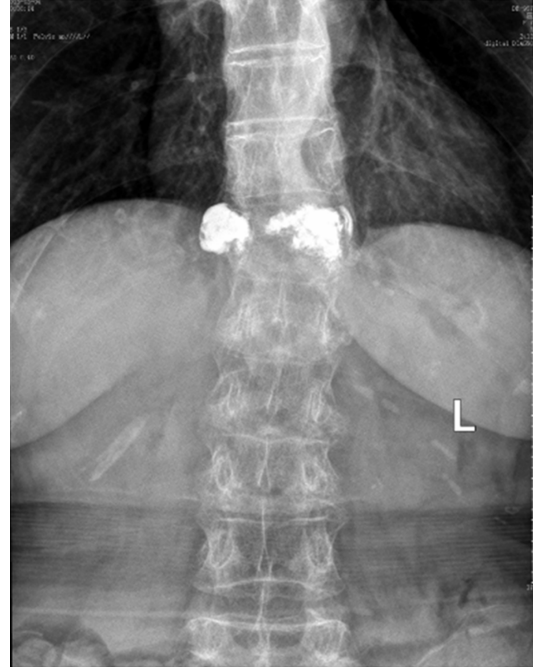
Twelve months after the kyphoplasty procedure, anteroposterior radiograph showed T12 vertebral body right lateral wedging.
